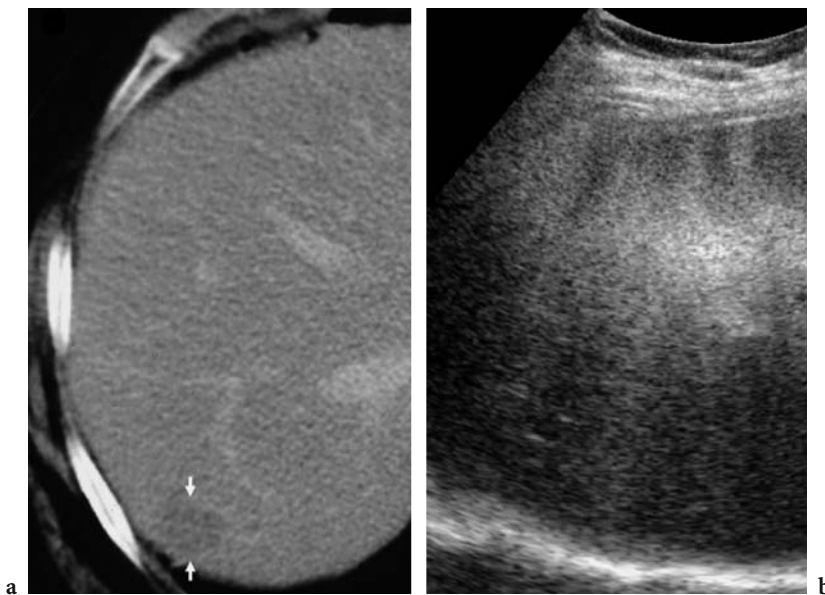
Improved lesion detection on contrast-enhanced CT in comparison with contrast-enhanced US. A single, very deeply located metastatic lesion (*arrows*) is seen on contrast-enhanced CT (a), while contrast-enhanced US (high acoustic power mode after air-filled microbubble injection) (b) does not identify any lesion.
